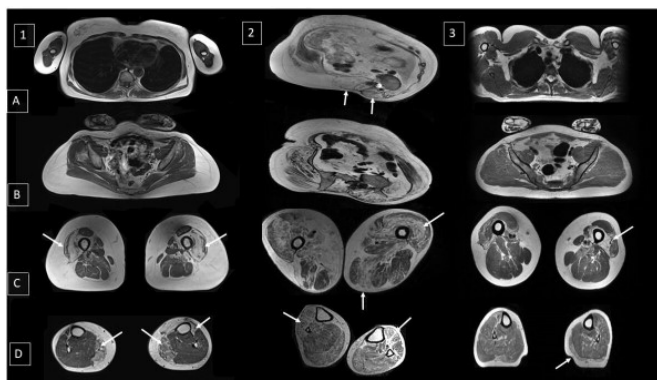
Muscle MRI patterns T1-weighted axial MRI images. Arms and trunk muscles (A); pelvic girdle (B); thighs (C); legs (D). (1) Laing distal phenotype. (C, D): fatty replacement of tibialis anterior, vastus lateralis, medialis and intermedius and gastrocnemius medialis (Mercuri grade 4, arrows). Mild fatty replacement of adductors magnus (Mercuri grade 2). (A, B): Pelvic girdle muscles, trunk and arms are well preserved. (2) Sphinx phenotype. (A, B): note the severe paravertebral fatty involvement (Mercuri grade 4) leading to major scoliosis and vertebrae rotation. (C, D): Fatty involvement of quadriceps, adductors magnus (Mercuri grade 3) whereas gracilis and hamstrings are better preserved. In legs, the fatty involvement is more pronounced in the tibialis anterior (Mercuri grade 3) than in the posterior compartment (Mercuri grade 2). (3) Atypical MRI phenotype (clinically Laing distal phenotype) (C, D) Atypical pattern of asymmetric fatty replacement of vastus intermedius and medialis, more pronounced on the left side (Mercuri grades 4 and 3, respectively). Note the fatty involvement of the left gastrocnemius medialis (Mercuri grade 3). (A, B): Pelvic girdle muscles, trunk and arms demonstrate normal appearance.
